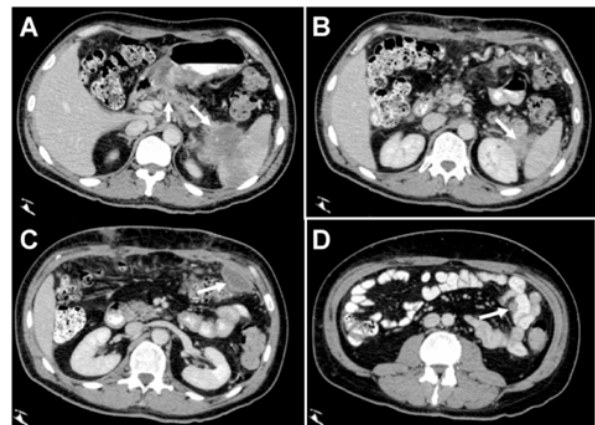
Pretreatment axial computed tomography (CT) scan images. A) Primary pancreatic mass involving the body and tail of the pancreas and invading the spleen and stomach. B) Involvement of the left perinephric fat. C) Large omental tumor implant. D) Mesenteric tumor implant.
